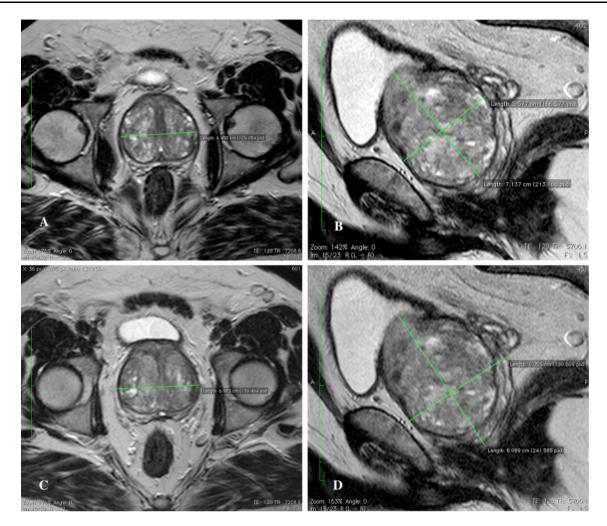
T2-weighted pelvic MRI in axial and sagittal views exemplifying CG (A, B) and WP (C, D) transverse, craniocaudal, and anteriorposterior measurements. In this case, patient presented with a favorable ZVi of = 0.748
